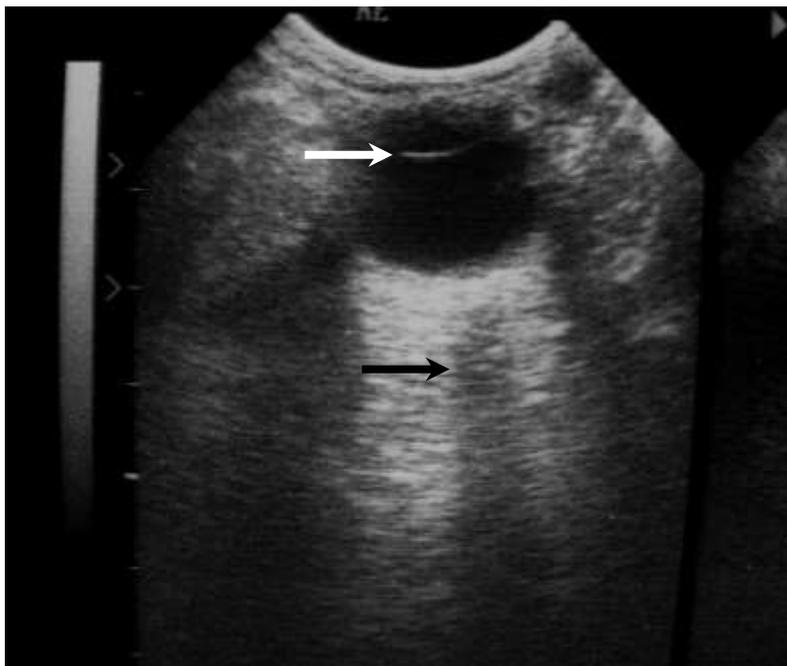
Sonogram of normal left eye. White arrow showing normal lens and black arrow showing optic nerve
